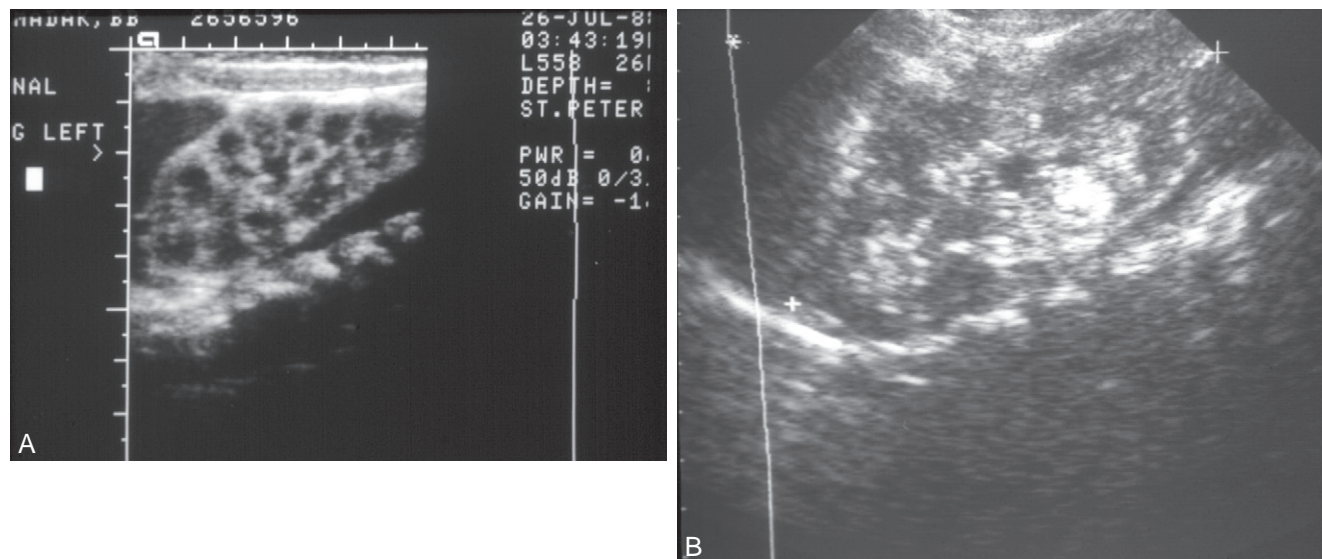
A, Multiple cysts are seen throughout the left kidney on this ultrasound study in a newborn with autosomal dominant polycystic kidney disease. B, Newborn with autosomal recessive polycystic kidney disease. Note the increased echogenicity and the small cysts. (Courtesy Walter Berdon, MD.)
